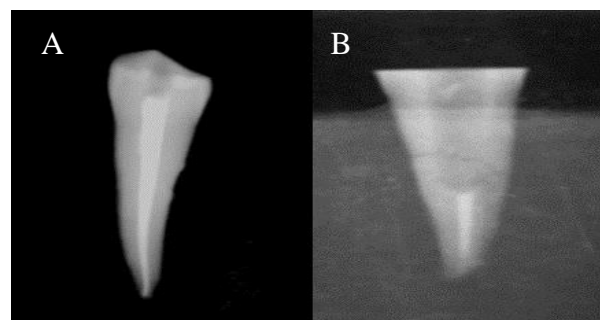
X-ray of a tooth A. After canal obturation and before flaring B. After canal flaring
